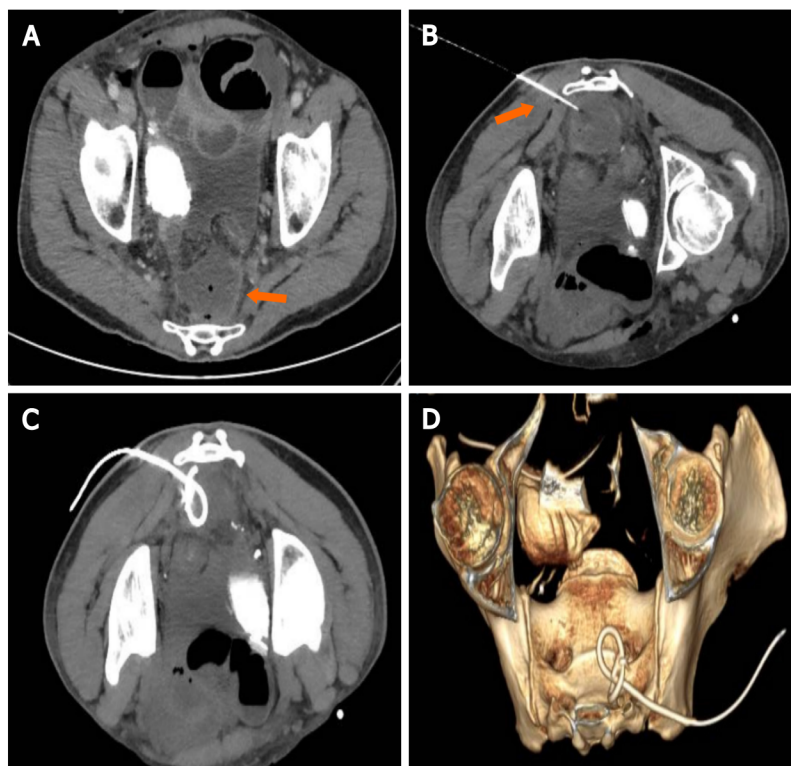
Presacral collection following rectal surgery. A: Axial computed tomography (CT) scan demonstrating a 4 cm × 3 cm presacral fluid collection (arrow), with small air bubbles; B: Patient in prone position, a Chiba needle is inserted with a trans-gluteal approach under CT guidance; C and D: Mip CT images and 3D Volume rendering reconstruction confirming the exact 8Fr drainage positioning.
